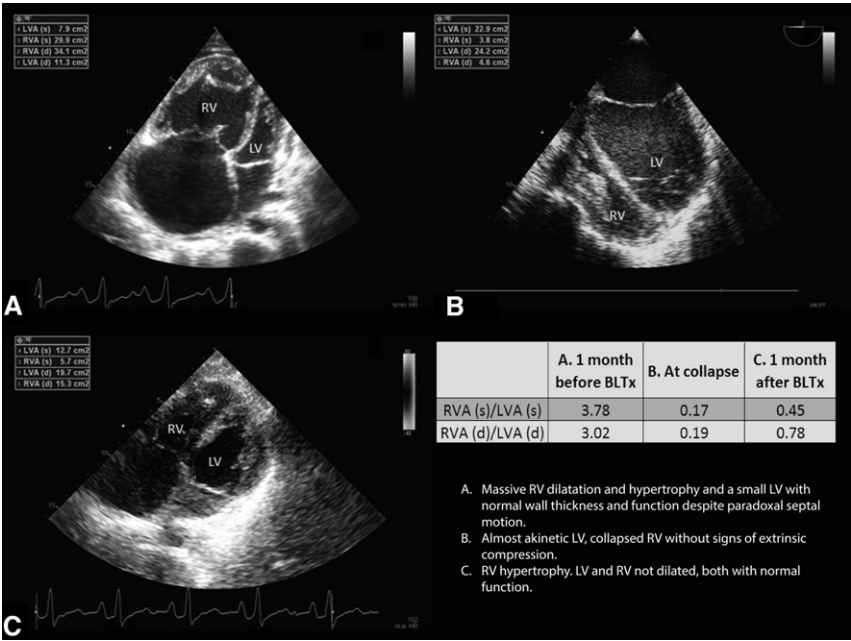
Echocardiographic images 1 month before bilateral lung transplant (BLTx; A), at collapse (B), and 1 month after lung transplant (C). LV, Left ventricle; LVA (d), diastolic left ventricular area; LVA (s), systolic left ventricular area; RV, right ventricle; RVA (d), diastolic right ventricular area; RVA (s), systolic right ventricular area.
